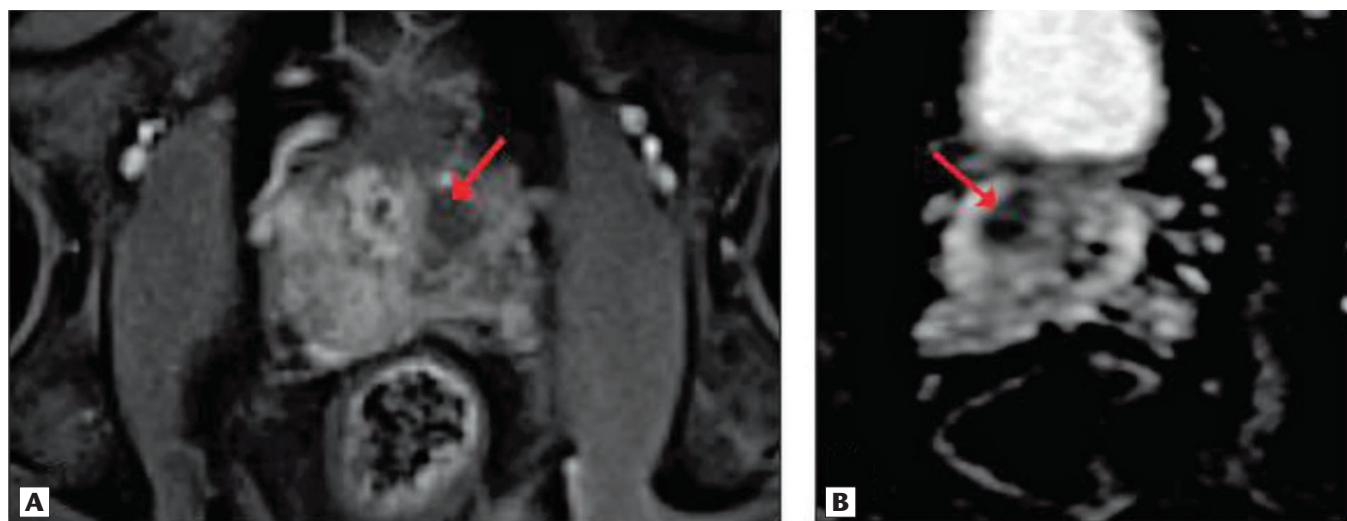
Postsurgical MRI.
